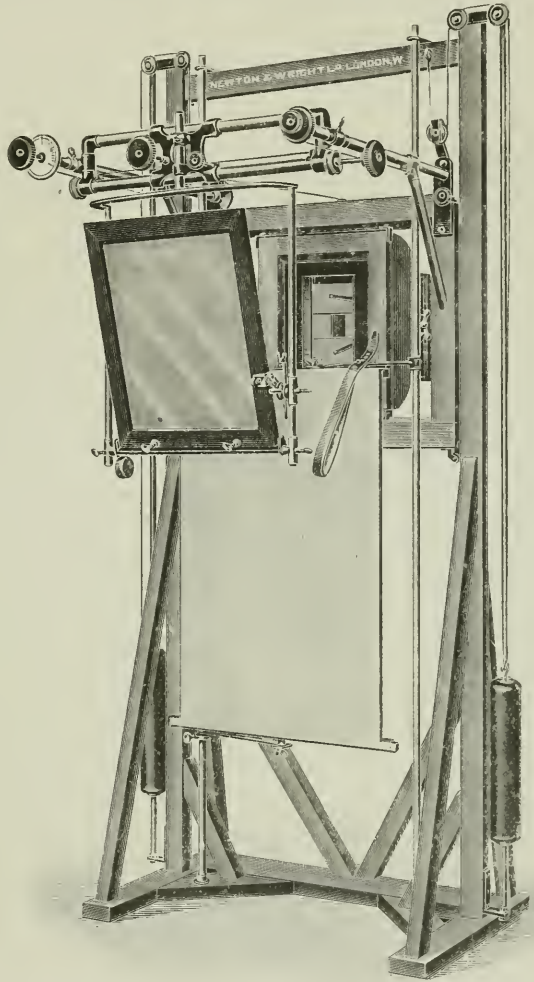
Upright screening stand, suitable for taking radiographs of the thorax. (Newton & Wright.) For stereoscopic work a rapid plate-changing device must be added. See Fig. 99, p. 106.
